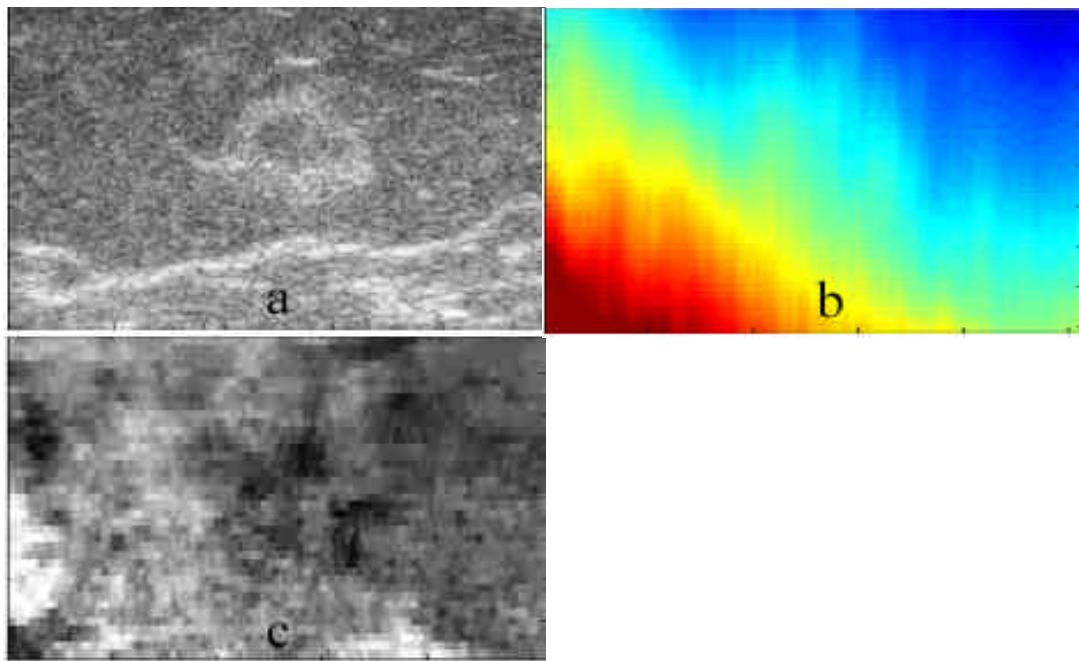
Sonogram (a), displacement map (b) and elastogram (c) of a 5 mm IDC (53 years old patient). A bulge around the lesion is observed on the displacement map. The IDC is less clearly detected (less contrast) on the elastogram.
